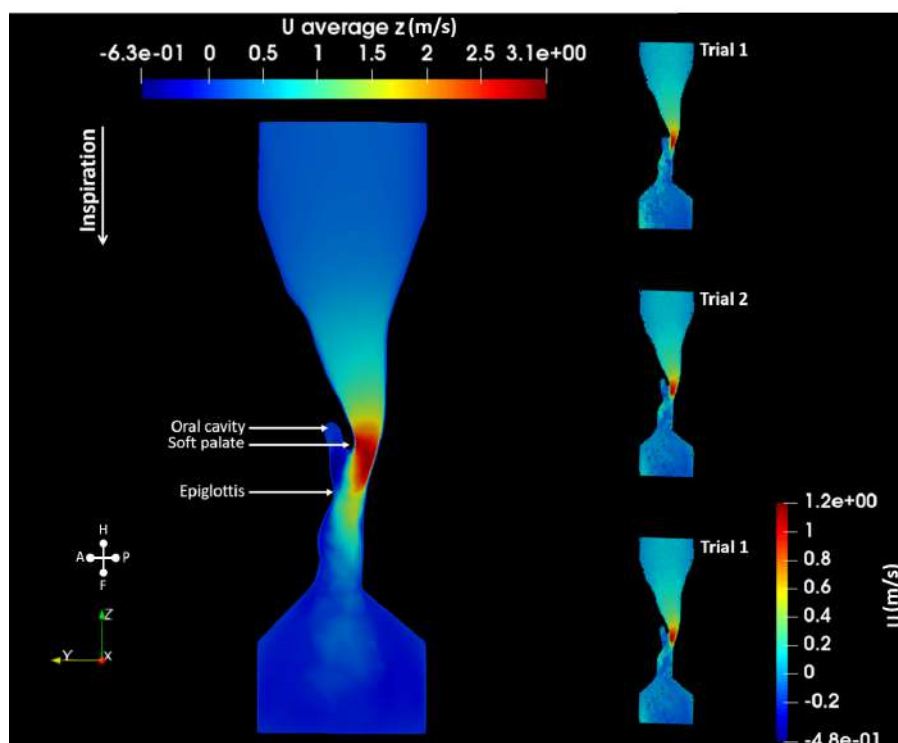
Sagittal slice of the CFD and 2D PC-MRI pharynx model showing flow separation during inspiration.
